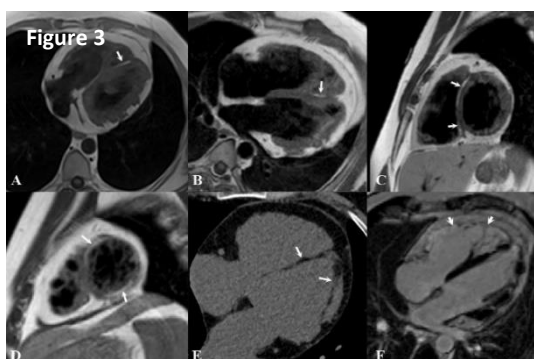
Cardiac MR and computed tomography (CT) studies of 35-year-old male patient with diagnosis of ARVD/C. On 4CH T1-WI (A,B) and SA (C,D) studies there was high signal intensity representing fatty tissue infiltration at the right portion of interventricular septum and in the subepicardial region of the left ventricle wall (white arrows). Long axis cardiac CT images (E) show the low density fatty tissue infiltrations at left ventricle lateral wall and the septum (white arrows). Post-contrast imaging (F) depicts contrast material enhancement which represents fibrosis at right ventricle wall (short arrows).
